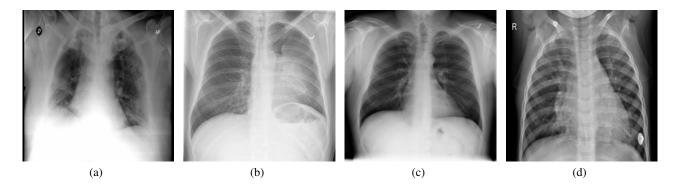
Examples of chest X-ray images: (a) COVID-19, (b) Lung Opacity (c) Normal, and (d) Viral Pneumonia.
